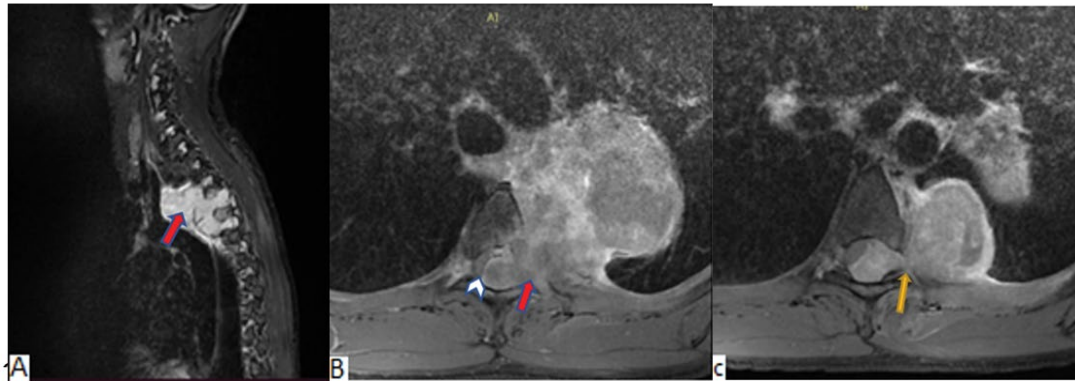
A 35-year-old patient presented with progressively worsening low back pain complicated by paraplegia and sphincter dysfunction. Spine MRI showed a left posterior mediastinal process at D5-D6, T2 hyperintense (A), enhanced after injection (B,C), enlarging the vertebral hole (red arrow), resulting in spinal cord compression (arrow head) (B), with hourglass intracanal extension (yellow arrow) (C). A partial resection was performed followed by chemotherapy.
